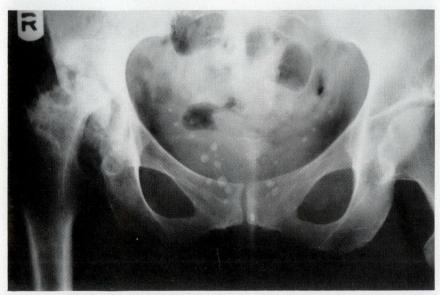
Case 3. Preoperative x-ray film showing marked erosion of acetabulum and superior migration of femoral head.
